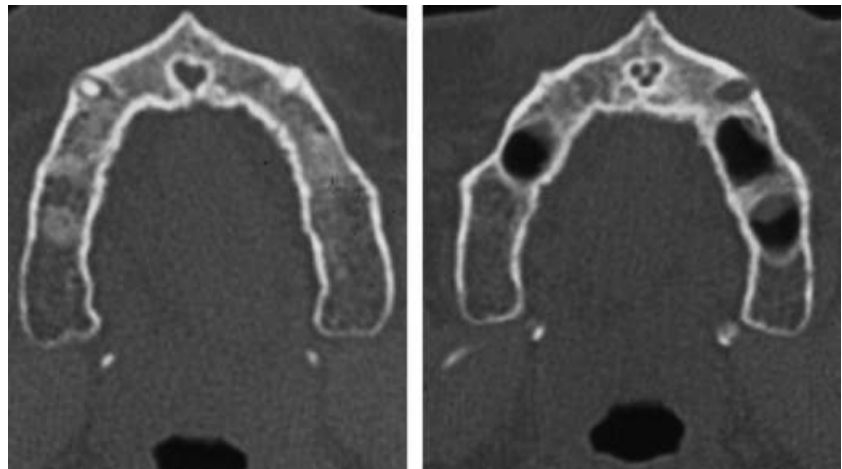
Axis images from spiral computed tomography scanner show the cone shaped canal running into three canals in the nasal floor.
